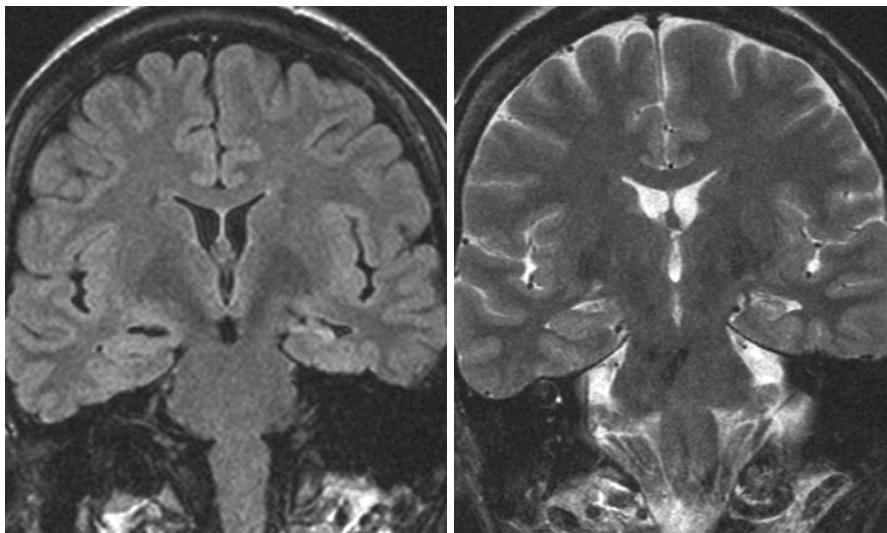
Coronal FLAIR (left image) and T2 (right image) MRI images on a patient with left MTS. Note FLAIR signal changes and smaller hippocampal size on the left. (Image Courtesy of Dr. Anton Hasso)
